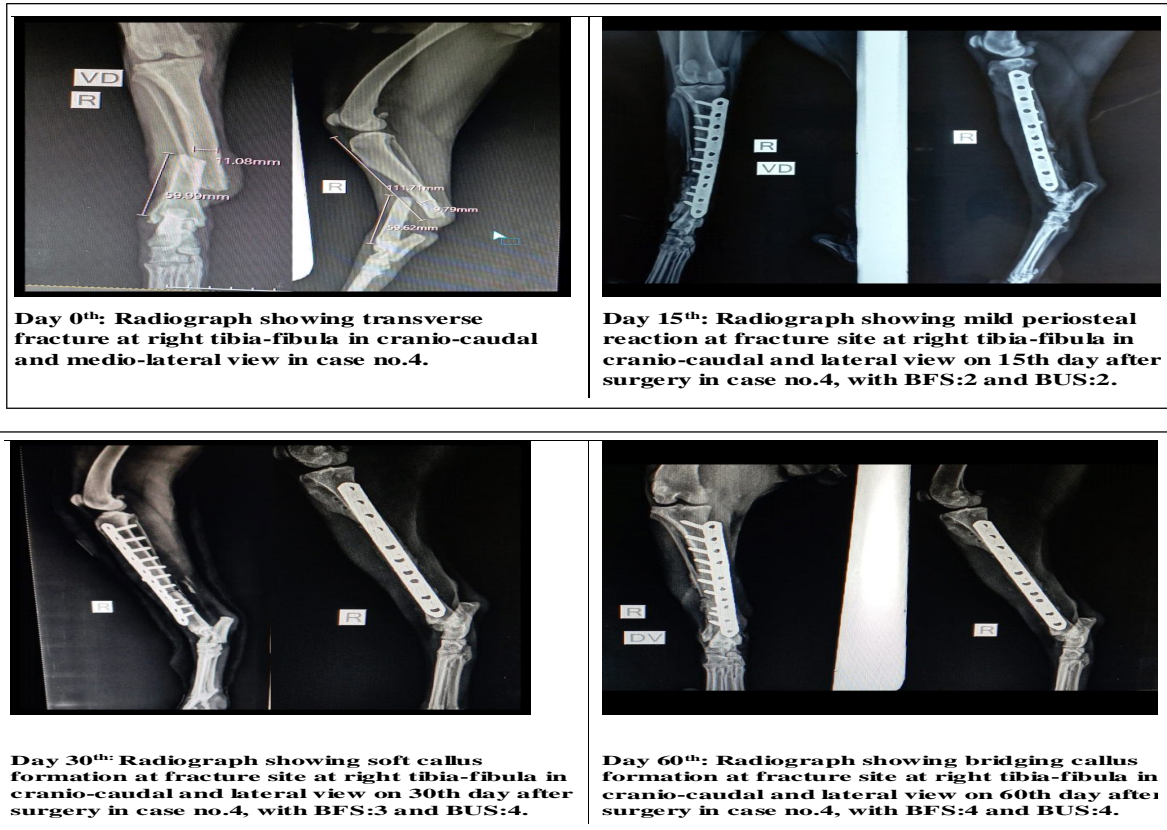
Radiographic evaluation of fracture healing at periodic intervals
